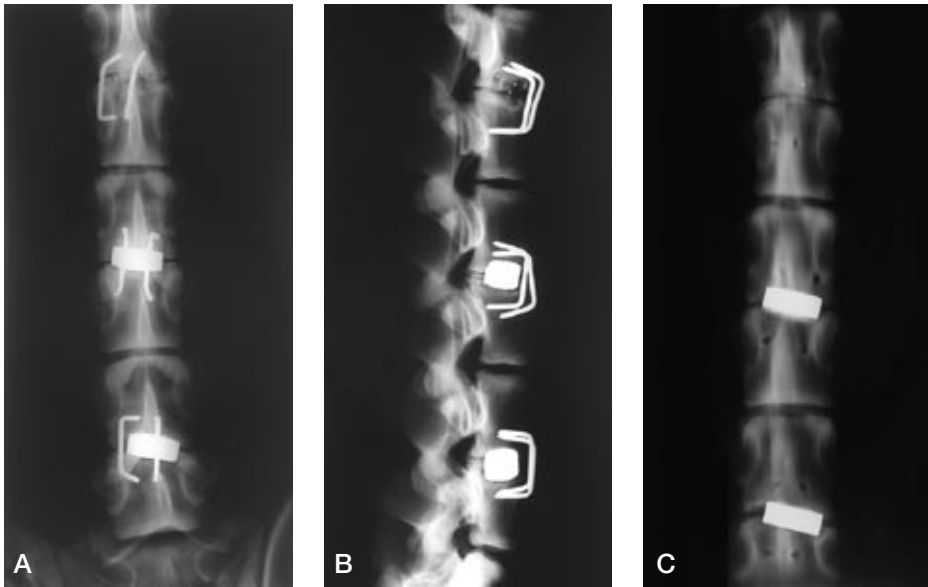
Plain posteroanterior (A) and lateral (B) radiographs and conventional tomograph (C).
